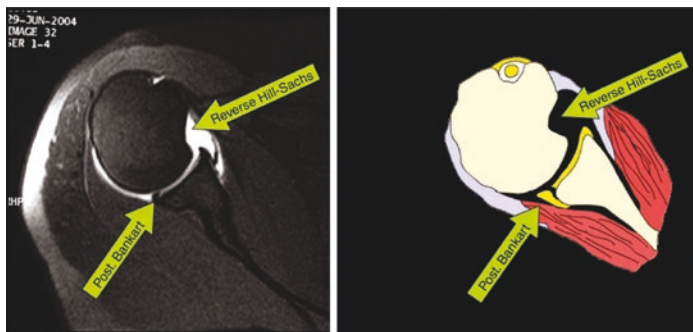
Reverse Bankart lesion (detachment of the posteroinferior labrum with avulsion of the posterior capsular periosteum) and reverse Hill-Sachs lesion (fracture of the anteromedial aspect of the humeral head) on MRI arthrogram [13]
